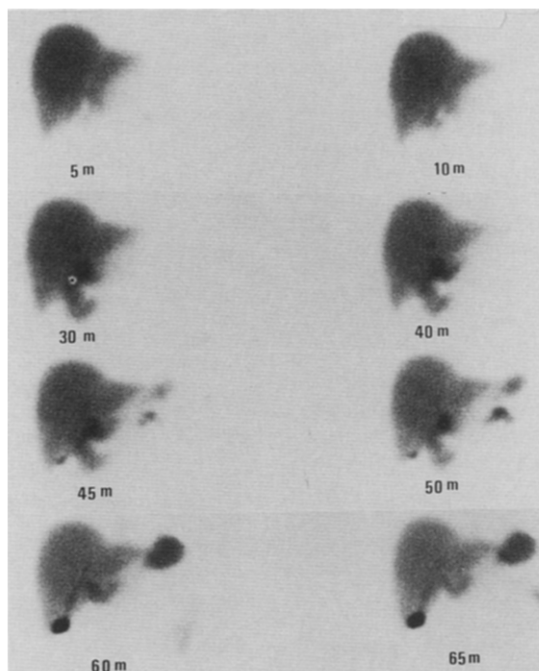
^{99m}Tc -DISIDA hepatobiliary scintigram shows rapid radiopharmaceutical concentration in the liver, appearance of bowel activity beginning at 10 minutes, and gallbladder activity seen after 45 minutes. There is also gradual accumulation of radiotracer in the stomach region in the images from 45 minutes to 65 minutes indicating duodenogastric reflux.
